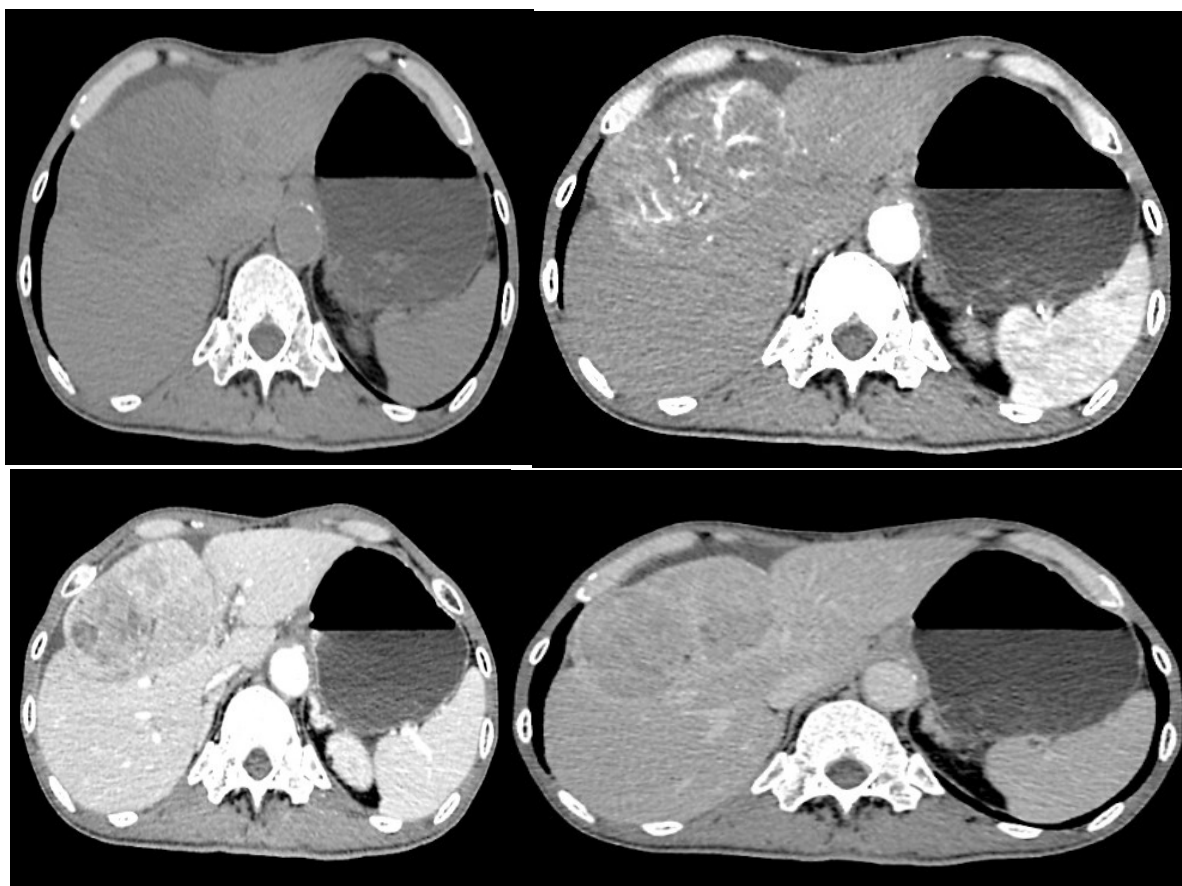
Axial CT images in (a) plain, (b) arterial, (c) porto-venous and (d) delayed phase. Hypervascular mass in segment VIII of liver which demonstrate arterial enhancement with washout in the porto venous and delayed phase.
